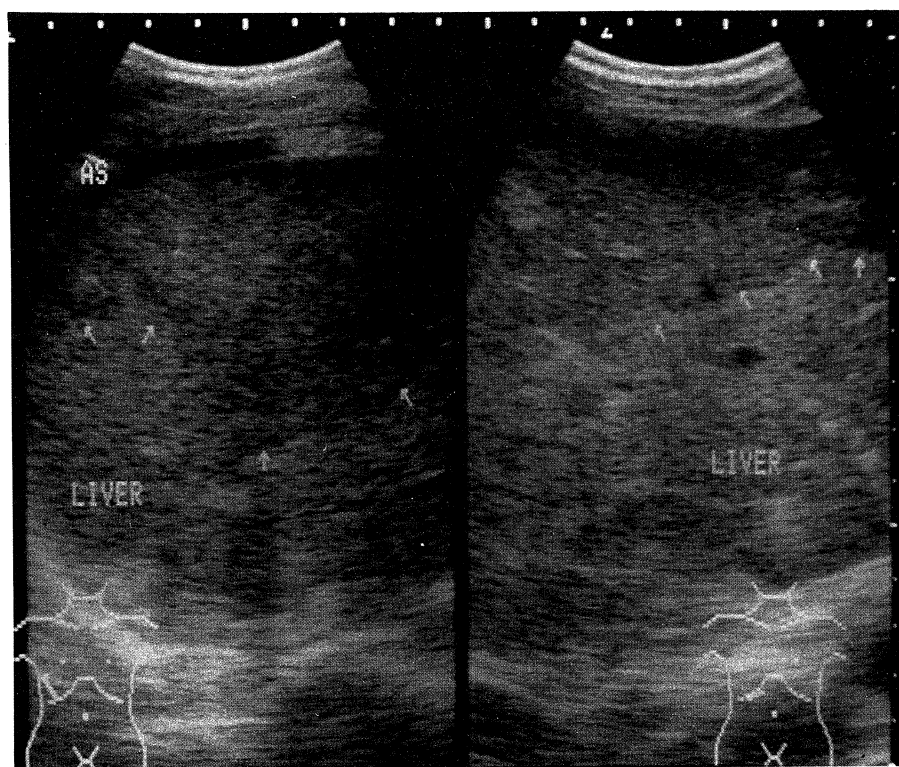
An abdominal ultrasonography on admission
